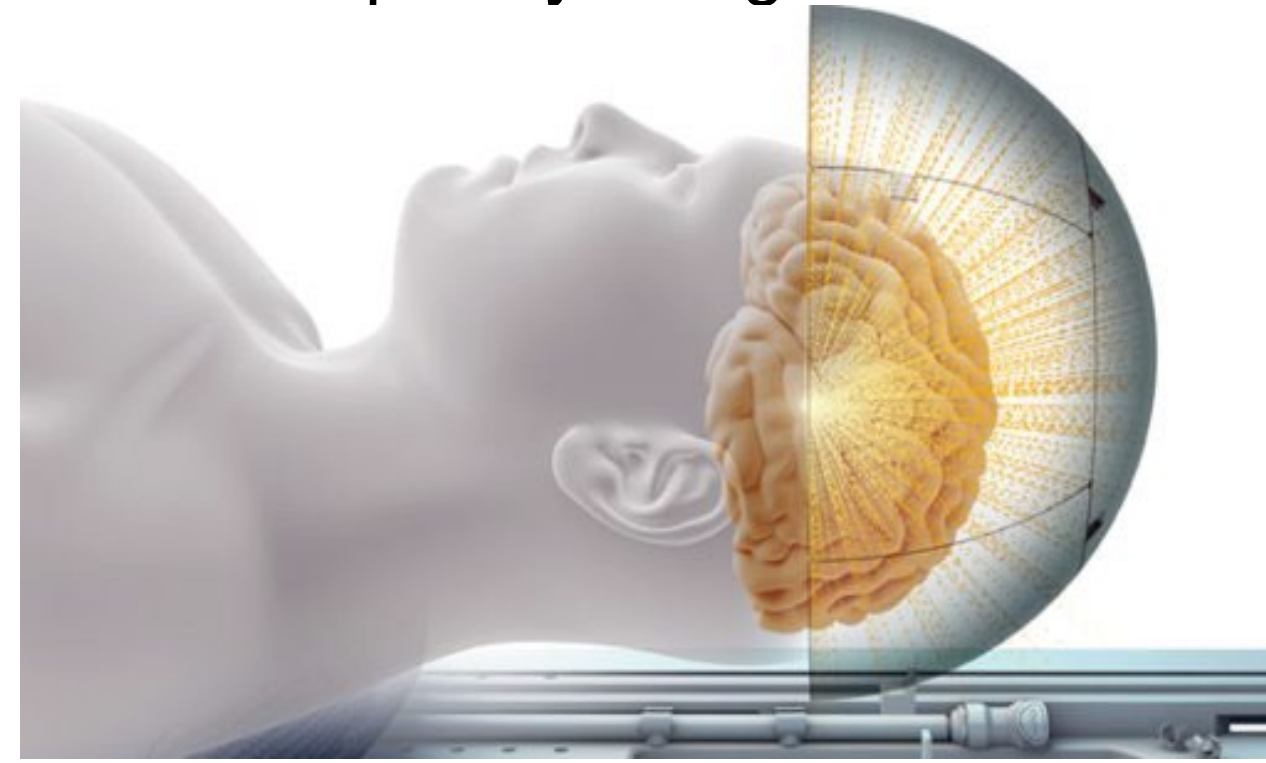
Theoretical approach to MRgFUS including the use of many ultrasound waves focused to ablate one target in 3D space.
